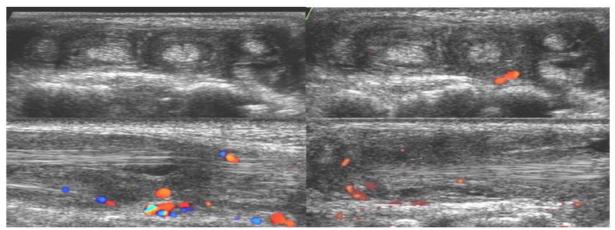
Extensor tenosynovitis. (a) Transverse US image with (b)Color Doppler, (c) Longitudinal Color Doppler and (d) Power Doppler US image showing extensive tendon sheath thickening involving all extensor tendons with hypoechoic tendon
